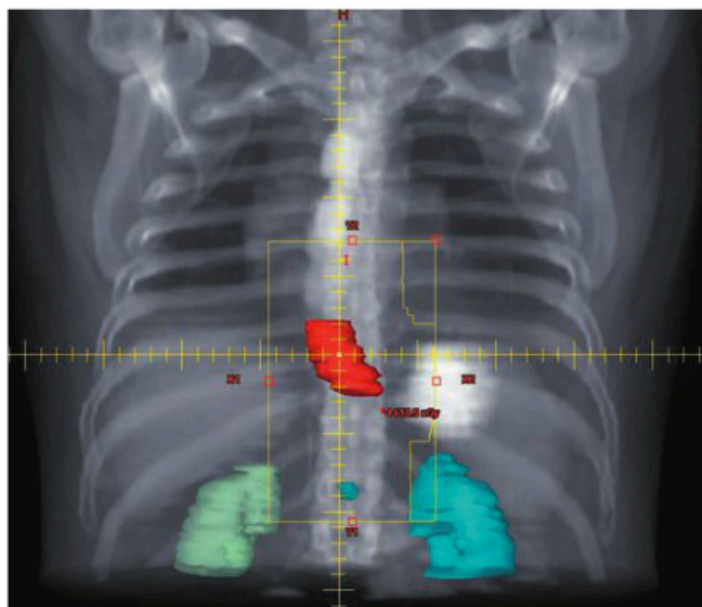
Digitally reconstructed radiograph for a typical lower esophageal lesion—AP view. gross tumor volume, red; celiac trunk, blue; right kidney, green; left kidney, blue (Courtesy of Rhonda May, CMD and Shiva Das, Ph.D.)
